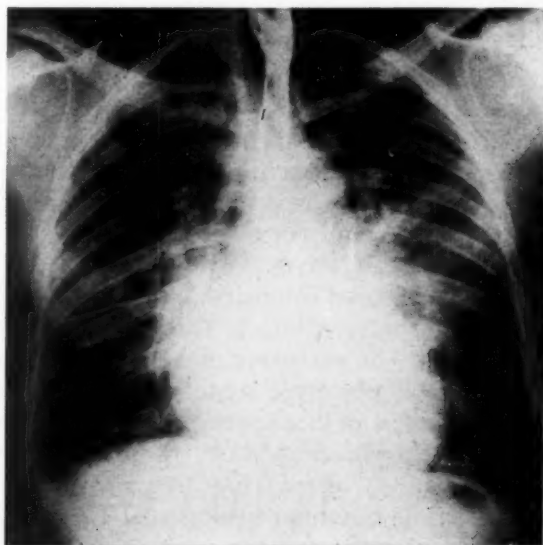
Roentgenogram of chest taken approximately 4 days after rupture of the aortic sinus, demonstrating globular enlargement of the heart and acute pulmonary congestion.
